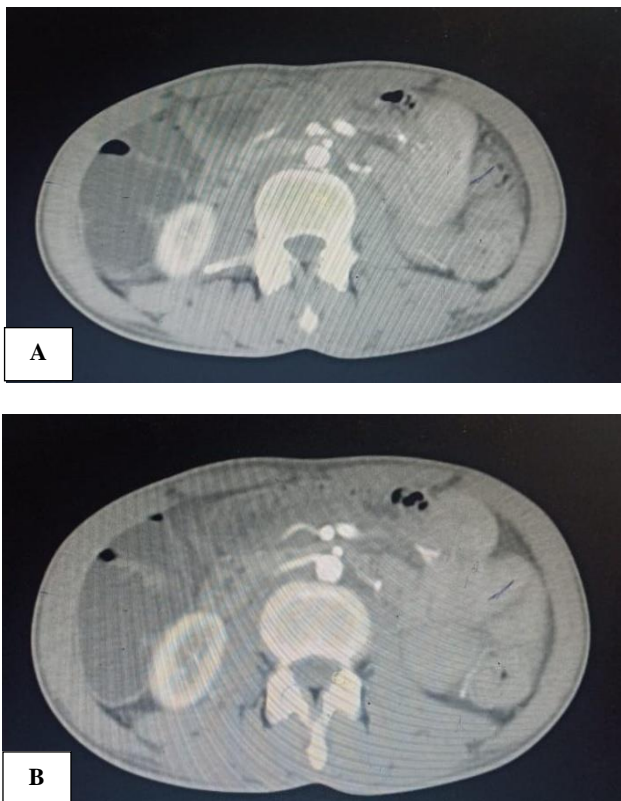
(A and B): CT abdomen showing fatty replacement of pancreas.
